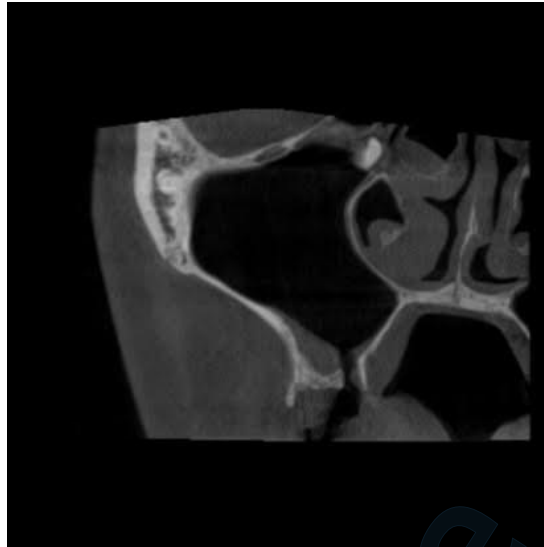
Oroantral communication associated with a displaced tooth in the maxillary sinus (CT scan). Courtesy of : Assist. Prof. Josip Biočić
